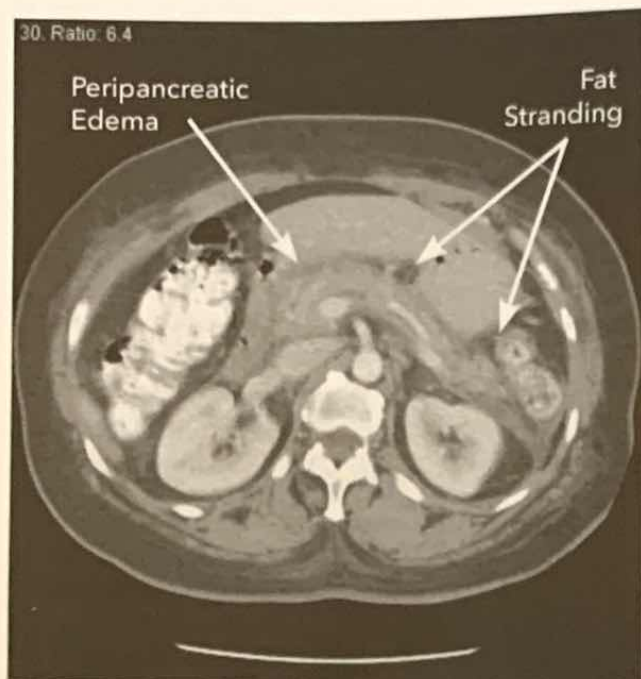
CT scan showing acute pancreatitis with peripancreatic fat stranding and inflammation. The hazy appearance of the mesenteric fat surrounding the pancreas in this image is called fat stranding, and the blurring of the margins of the pancreas is consistent with peripancreatic edema, features seen with inflammatory changes of acute pancreatitis.
